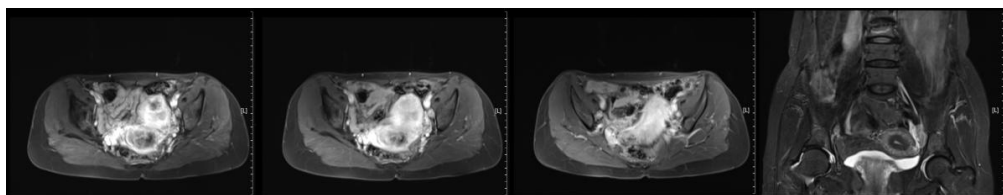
First discovery of pelvic MRI images on October 9, 2020
